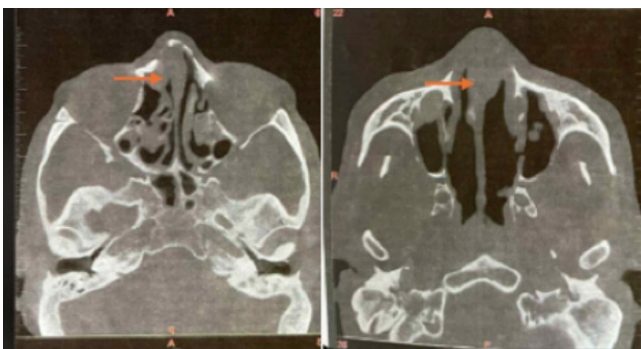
Axial CT images demonstrating septal thickening and bulging, with a left-sided hypodense septal collection causing marked narrowing of the adjacent nasal fossae.
